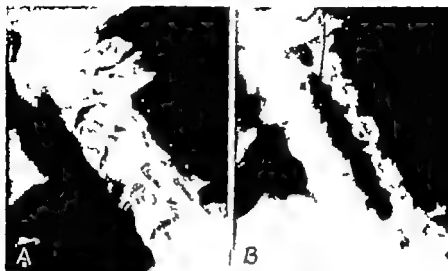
Radiographs of the cervical spine of a patient who has rheumatoid arthritis. Note the absence of bony encroachment of the intervertebral canals.
